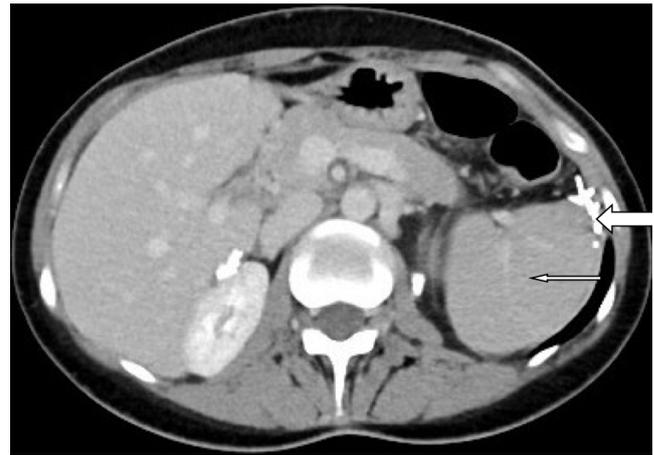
Contrast-enhanced abdominal CT in axial view: Splenic enhancement like capsular rim (thin arrow) with reduced parenchymal enhancement (thick arrow) located in the right lower quadrant
